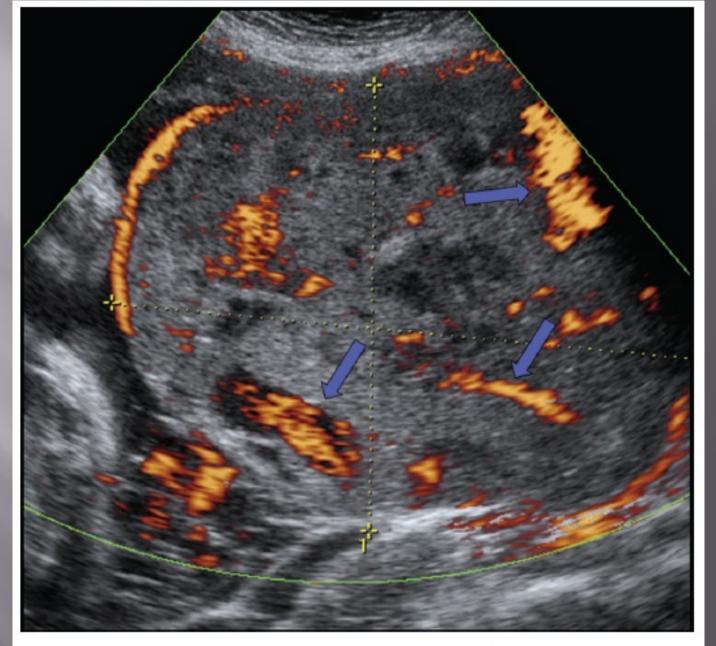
Ultrasound view of placenta. Highly vascular placenta with prevalent placental lacunae is shown (blue arrows).
